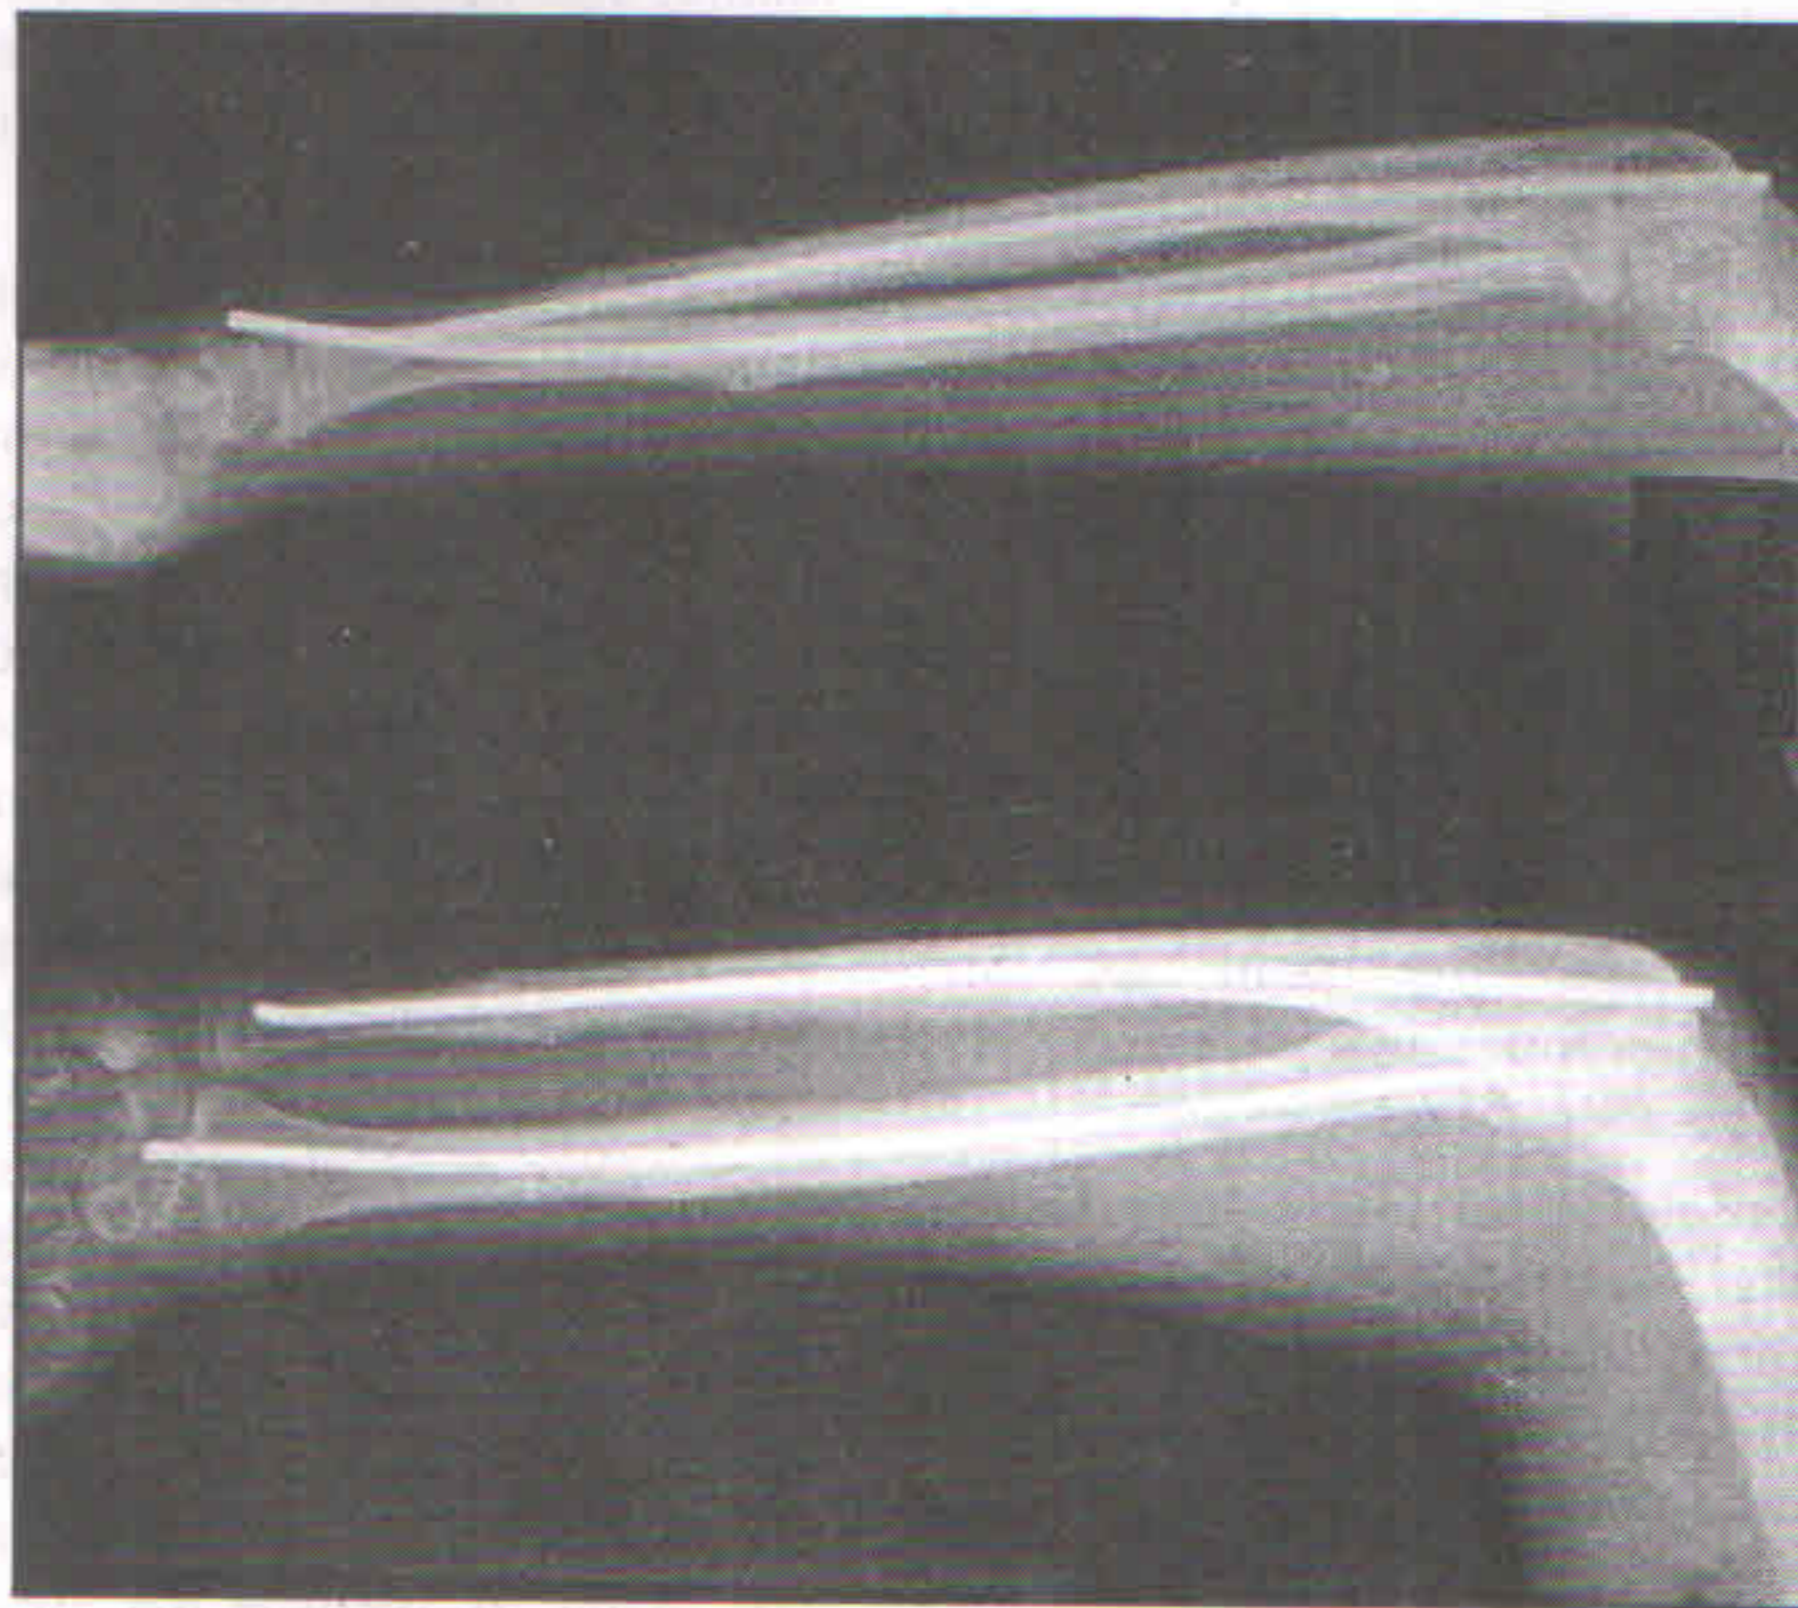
Xray of no forearm following union
